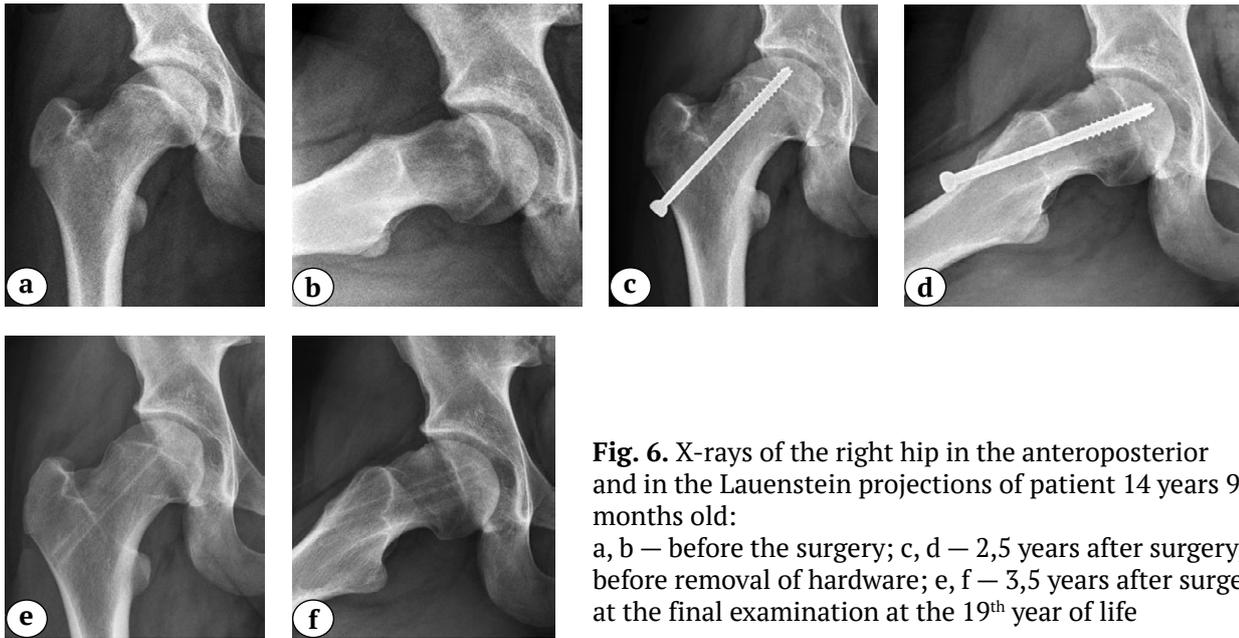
X-rays of the right hip in the anteroposterior and in the Lauenstein projections of patient 14 years 9 months old:
